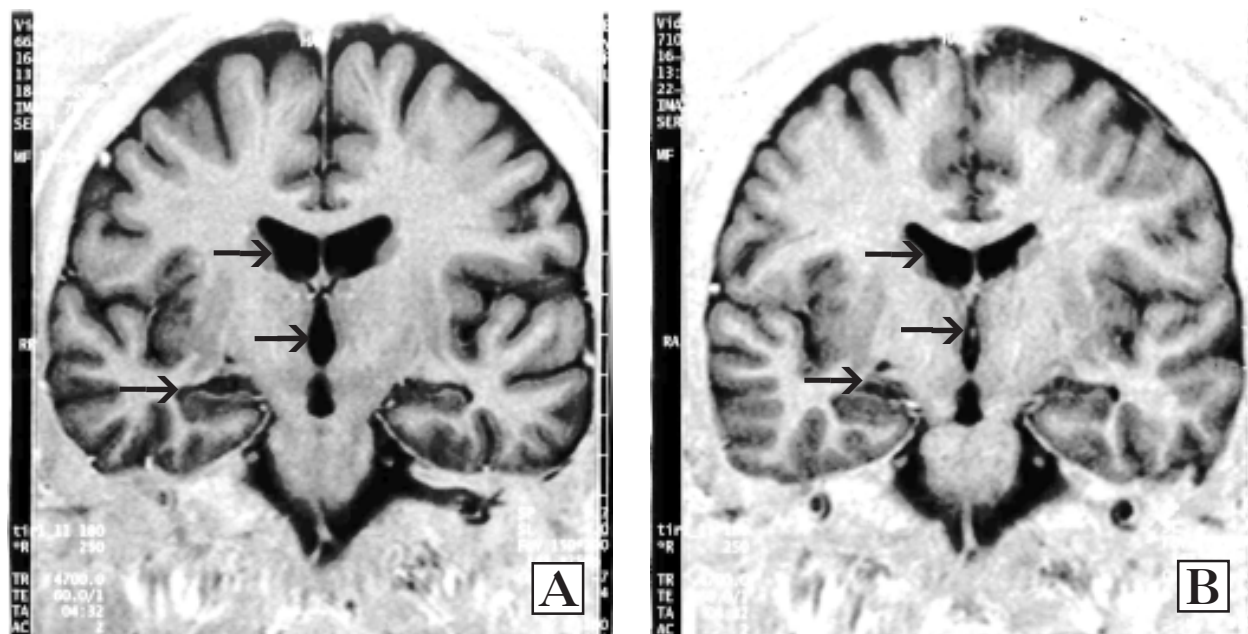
Magnetic resonance imaging, coronal plane, at the level of hippocampus in the monozygotic twin with (A) and without (B) schizophrenia. Arrows show enlargement of the lateral and third ventricles, smaller hippocampus, and more pronounced parietal and temporal cortical atrophy in the affected twin as compared with the unaffected twin.
